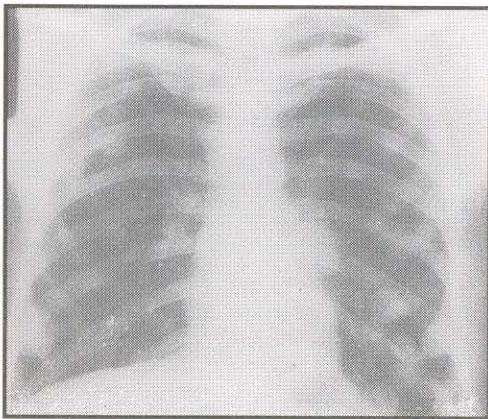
X-ray chest showing multiple lung metastasis.
